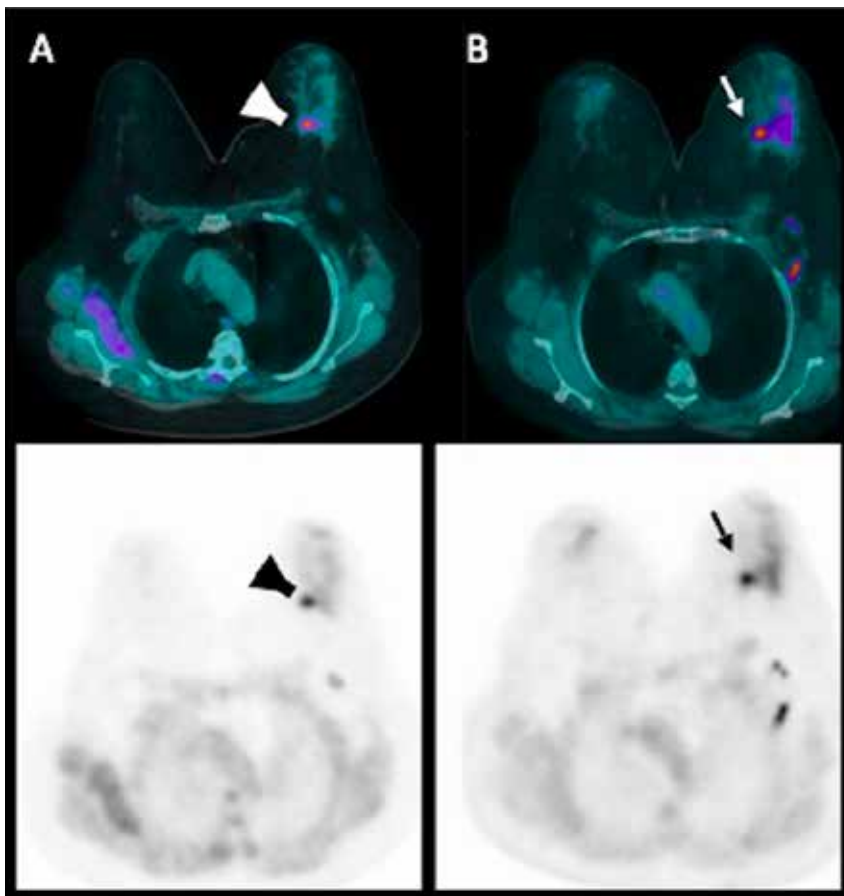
A. Axial fused $[^{18}\text{F}]$ FACBC PET/CT (top) and $[^{18}\text{F}]$ FACBC PET (bottom) demonstrating suspicious increased focal uptake in the left breast (arrowhead); B. Axial fused $[^{18}\text{F}]$ FES PET/CT (top) and $[^{18}\text{F}]$ FES PET (bottom) showing suspicious focal increased ER-expression in the left breast (arrow).
